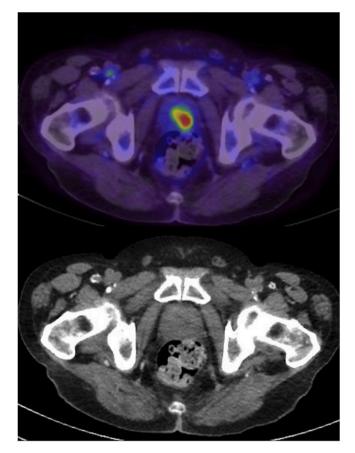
18F-FDG PET/CT axial images demonstrating high intensity in the left aspect of the prostate on fused image (above) correlated with fluid density on CT (below).
